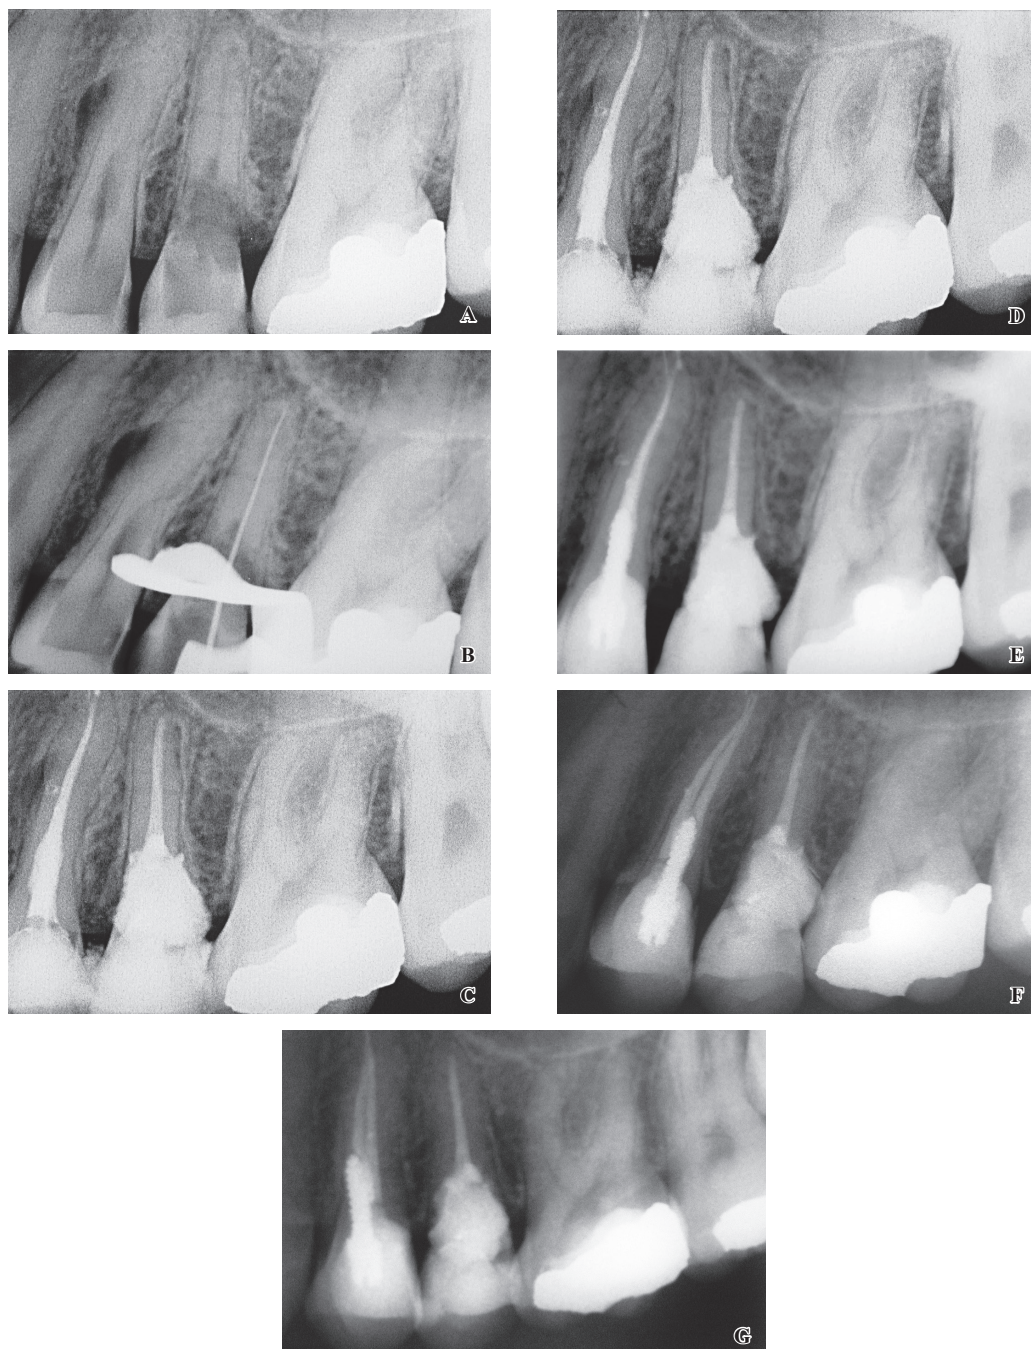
A, Pre-operative periapical radiograph showing extensive resorption of the upper left second premolar tooth. There is also root resorption and a lateral radiolucent lesion associated with the upper left first premolar tooth. B, Working length determination of the upper left second premolar tooth. C, Calcium hydroxide placement in the upper left second premolar tooth and working length determination of the upper left first premolar tooth. Also, note the instrument separation in the apical part. D, Post-operative periapical radiograph showed the jagged border of MTA in the upper left second premolar tooth. Also, the sealer extruded into the lateral canal of tooth 24 connecting the internal resorptive process with the external inflammatory lesion evidenced by the lateral radiolucency. E, A 12-month follow-up radiograph showing the excellent periodontal condition of the upper left second premolar tooth and clear evidence of healing of the lateral lesion associated with the internal inflammatory resorptive process within the upper left first premolar tooth. F, A 5-year follow-up radiograph showing crestal bone around the upper left second premolar tooth. Complete healing of the lateral radiolucent lesion associated with the upper left first premolar tooth can be seen. G, Another 5-year follow-up radiograph from a different angle.
